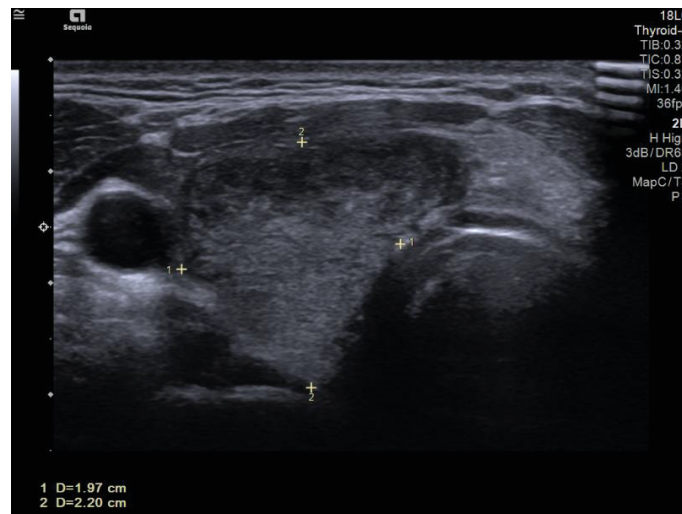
Thyroid US image demonstrates enlarged thyroid gland (1.97 × 2.20 cm) with heterogeneous echotexture granuloma at the patient's second visit to hospital. US = ultrasound scan.
